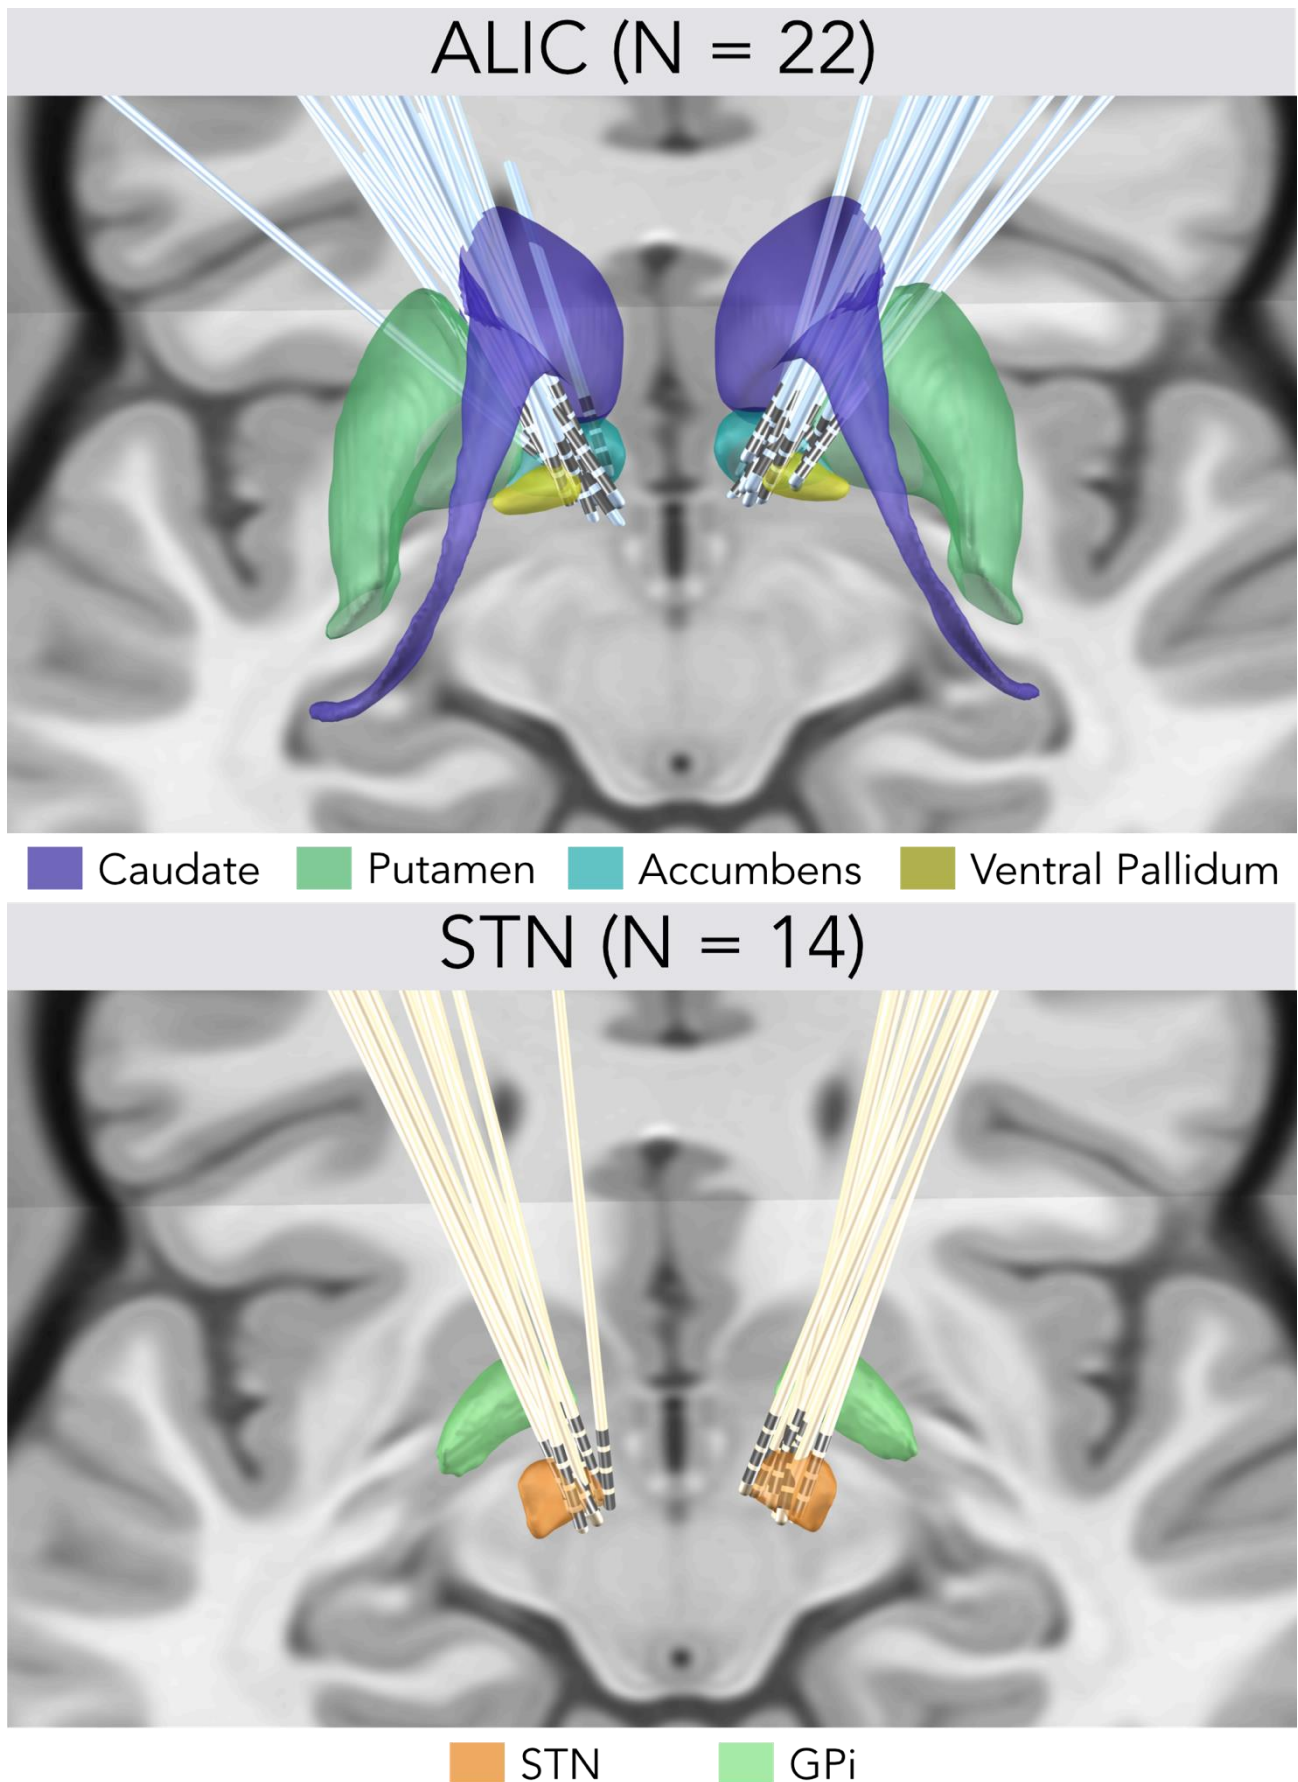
Overview of the lead electrodes placements of both ALIC DBS and STN DBS cohorts. Subcortical structures defined by CIT168 Reinforcement Learning Atlas ³¹ (ALIC cohort) and DISTAL Atlas ³² (STN cohort), with coronal and axial planes of the T1-weighted ICMB 152 2009b nonlinear
